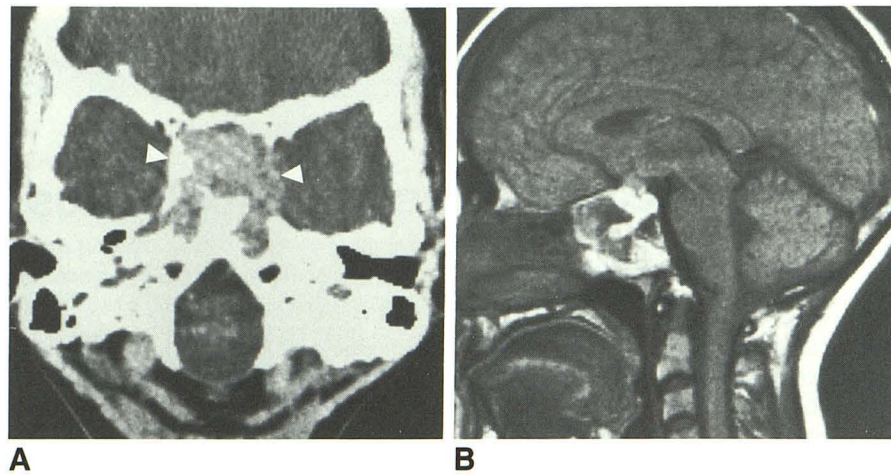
A, Axial CT scan with contrast shows modest enhancement of, and bone destruction by, mass (*arrowheads*).
